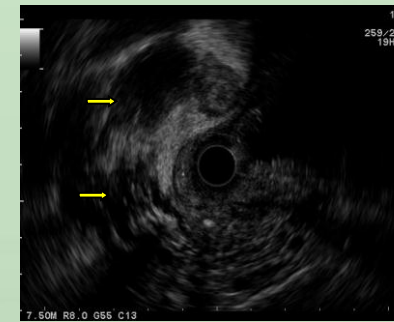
Liver lesions as seen on the endoscopic ultrasound (arrows).
